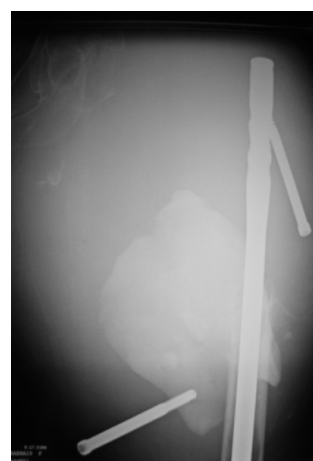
Antero posterior radiograph of the proximal femur one year after completion of radiation therapy revealed resorbed proximal femur and failed device
